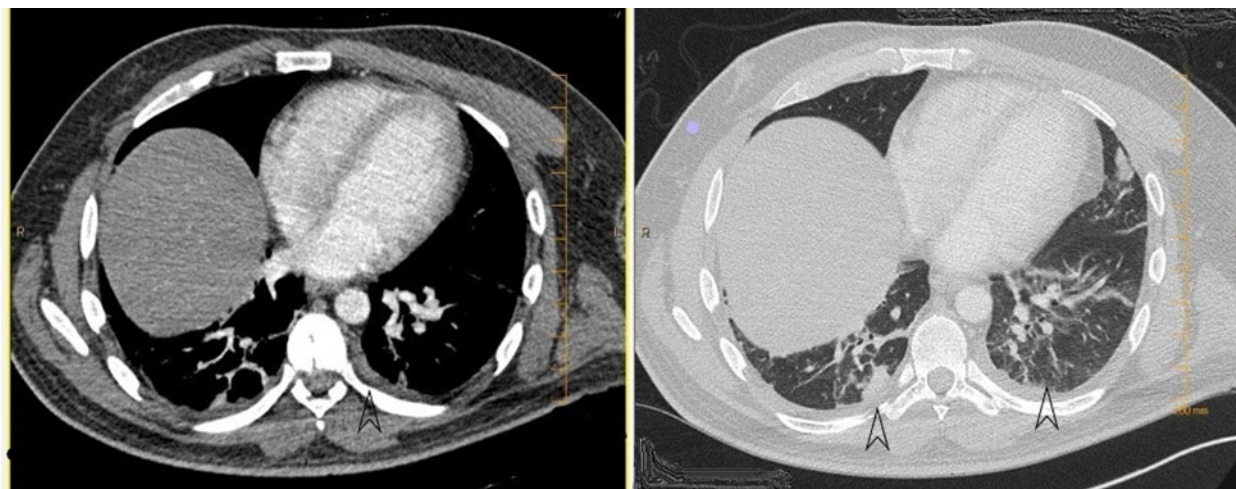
CT chest showing consolidation of lung bases
